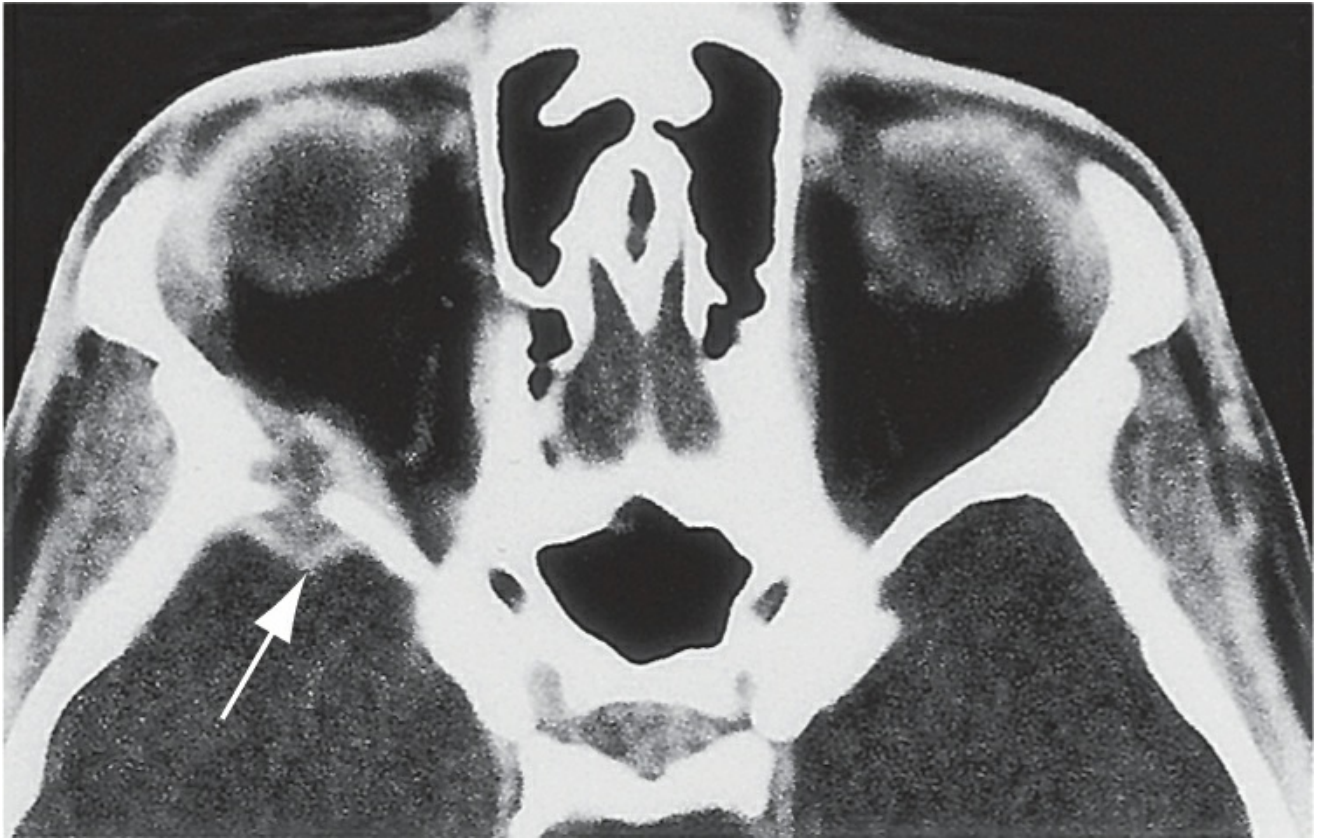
Axial CT image showing unifocal eosinophilic granuloma with partial destruction of the right posterior lateral orbital wall (arrow) in a 15-year-old boy, who presented with retrobulbar pain and mild edema and erythema of the right upper eyelid.
